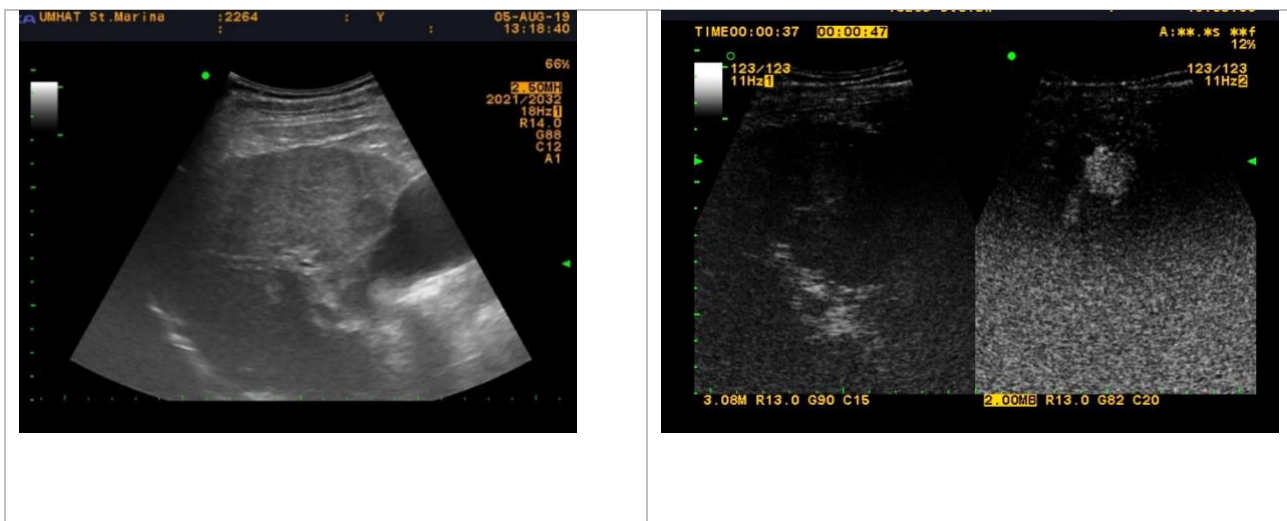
B-mode and Doppler ultrasonography in a patient with HBV cirrhosis
